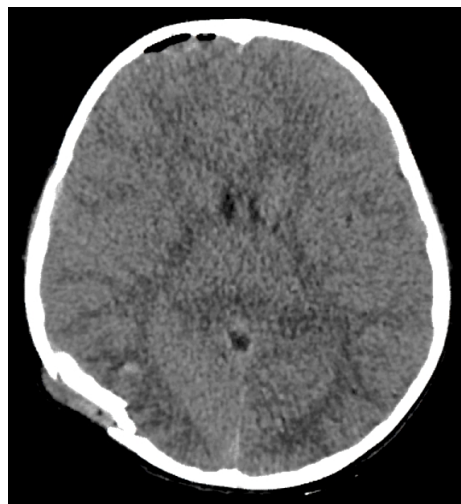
Non-contrast CT of the head showing right occipital depressed fracture with frontal pneumocephalus which indicates dural tear, as per operative data.
